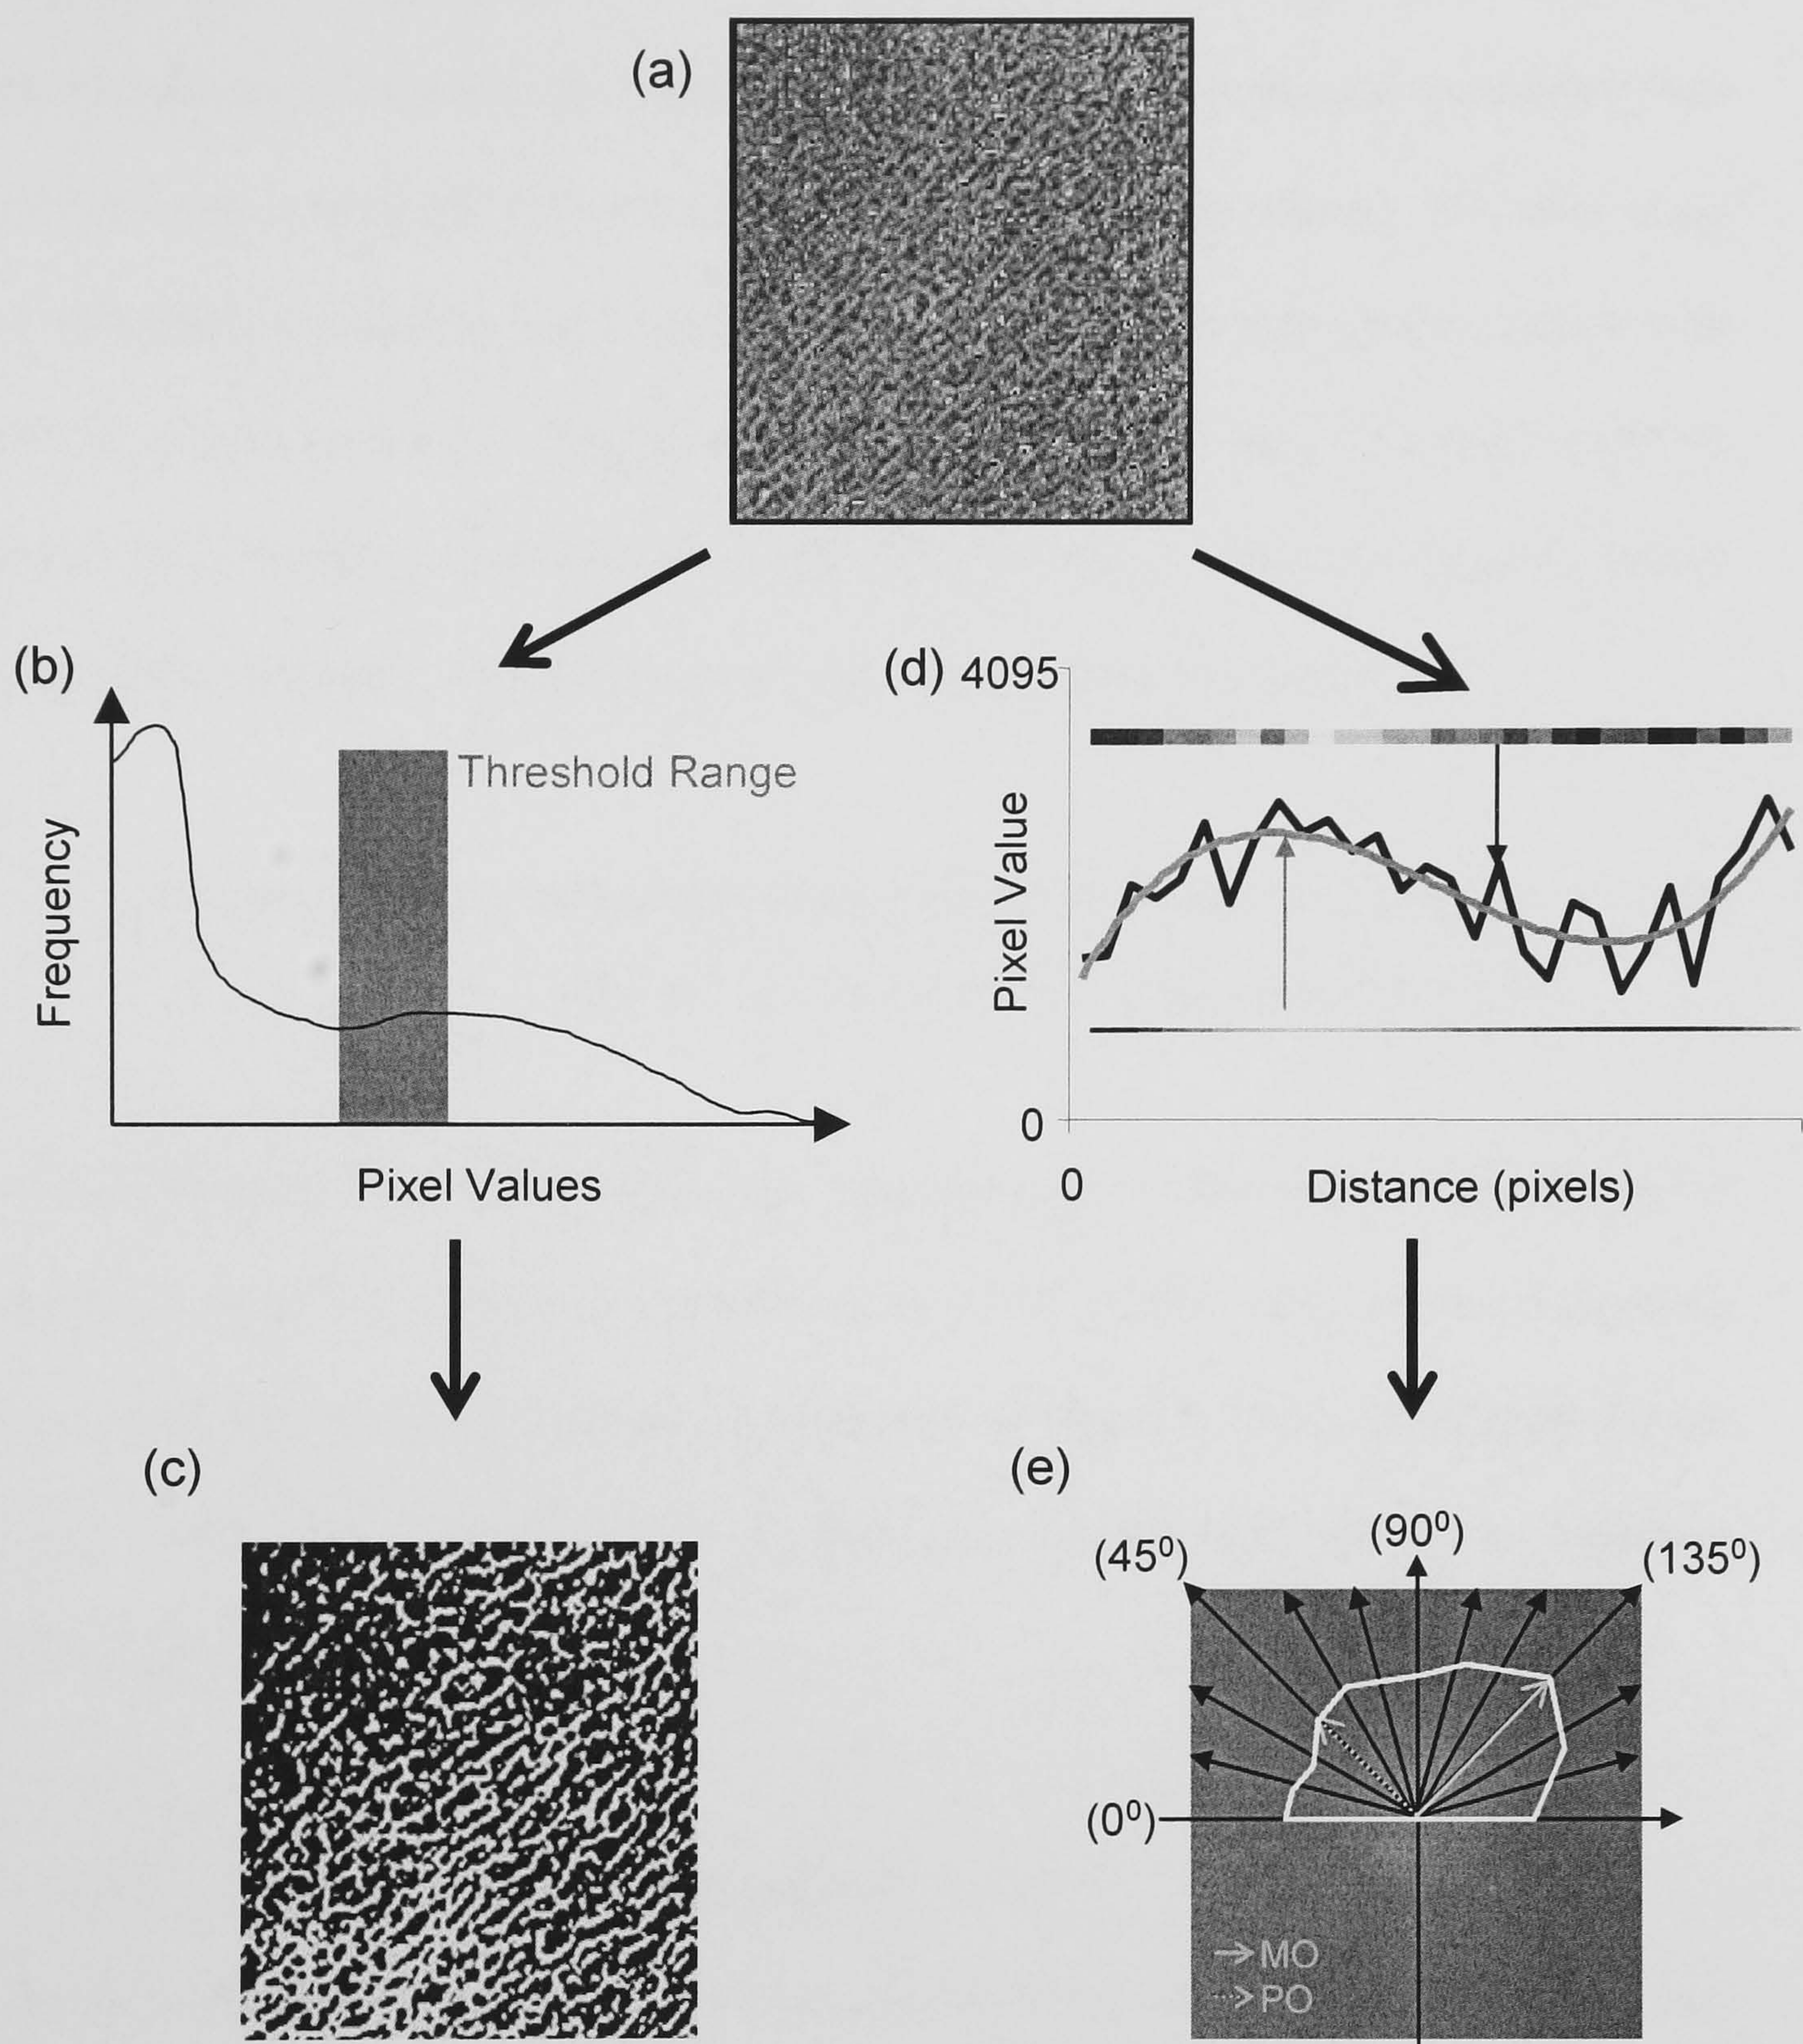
Quantifying trabecular material properties in the iliac blade. (a) Radiographic area of interest (b) Binary threshold procedure (lowest frequency used as lower boundary and second maximum set as upper boundary) (c) Binary threshold where pixels representing bone are coloured white and non-bone pixels are designated black (d) One-dimensional FFT (repeated for every row then every column). The original grey value data is smoothed. (e) Two-dimensional FFT with a rose plot superimposed on top (white line). Black arrows demarcate the bins at 15° intervals. Grey arrows designate the main trabecular orientation (MO) and the orientation perpendicular to the MO (PO).
